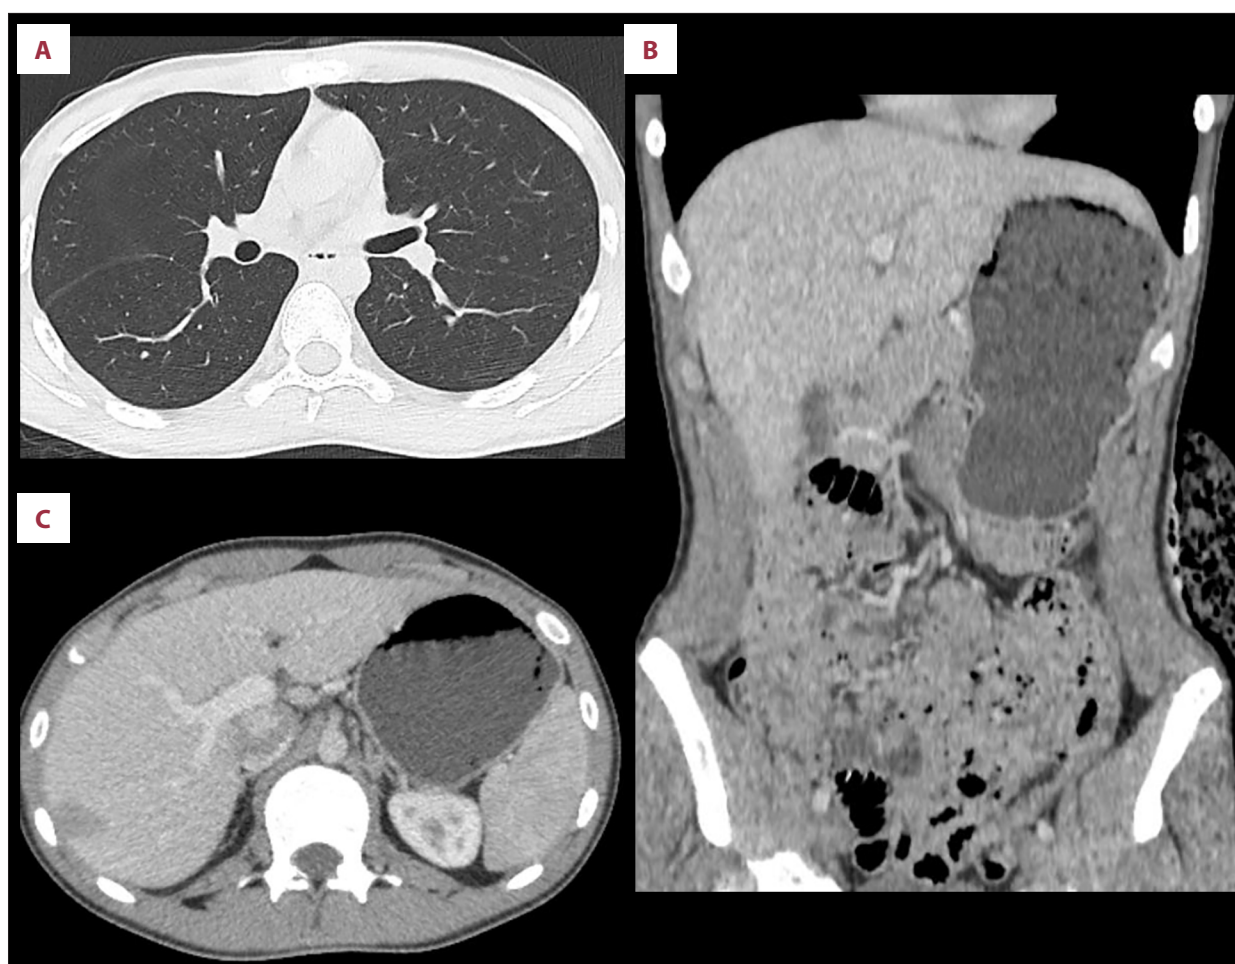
Follow-up contrast-enhanced computed tomography (CT) after completion of adjuvant chemotherapy. (A-C) CT images showing no radiological evidence of disease recurrence or metastatic progression. Postoperative findings remained stable, and no new lesions were identified.
